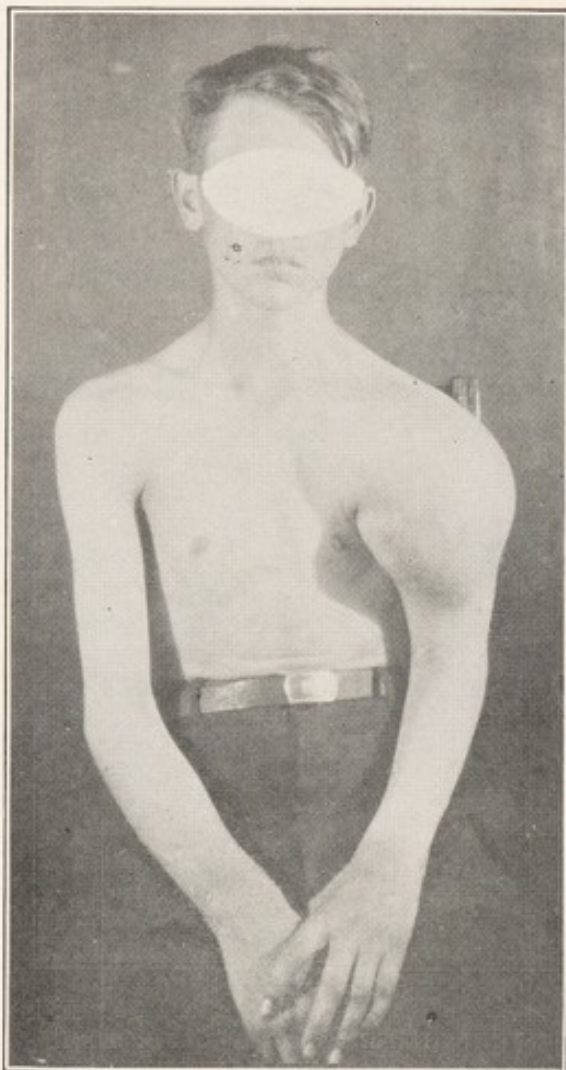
CASE OF OSTEOGENETIC SARCOMA OF HUMERUS OF WHICH X-RAY IS SHOWN IN FIGURE 145.
